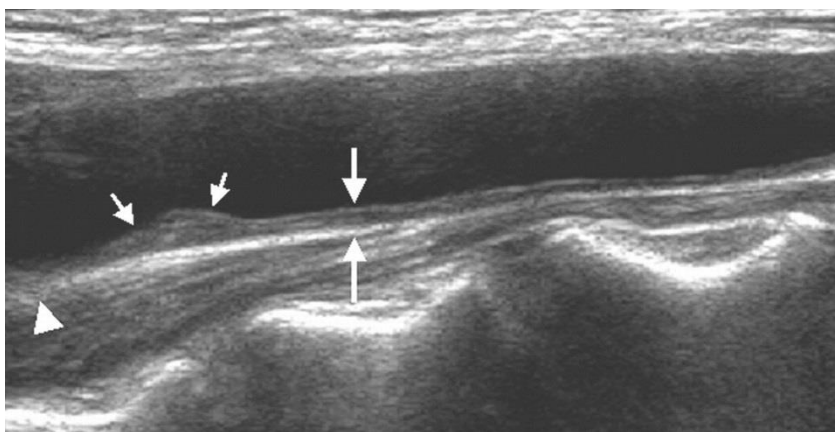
Example of a carotid ultrasonogram. Indications represent common carotid artery-IMT (*large arrows*), carotid plaque (*small arrows*) and the carotid bifurcation (*arrowhead*). Adopted with permission from *American Journal of Neuroradiology*.¹⁸
